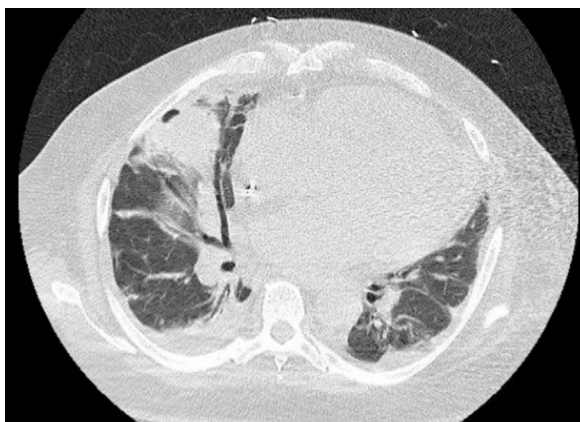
CT scan of the thorax: right lung base cavitory lesion significantly reduced
